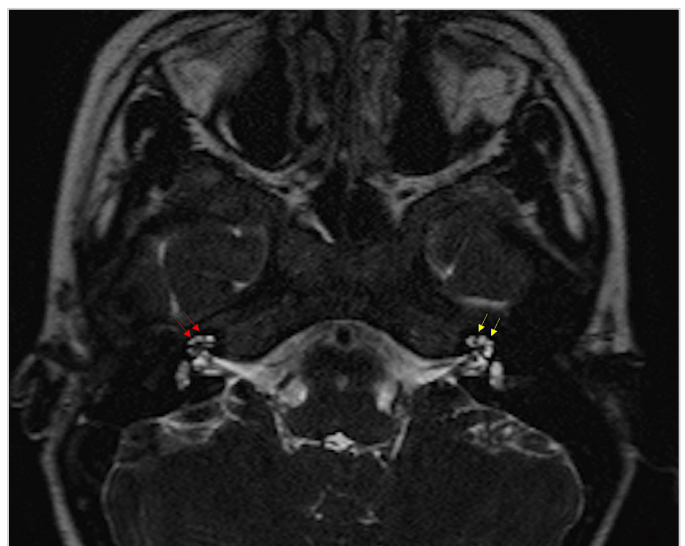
T2-weighted magnetic resonance images with axial cuts showing loss of hyperintensity in the basal turn of cochlea bilaterally (red arrow on the right and yellow arrow on the left)
